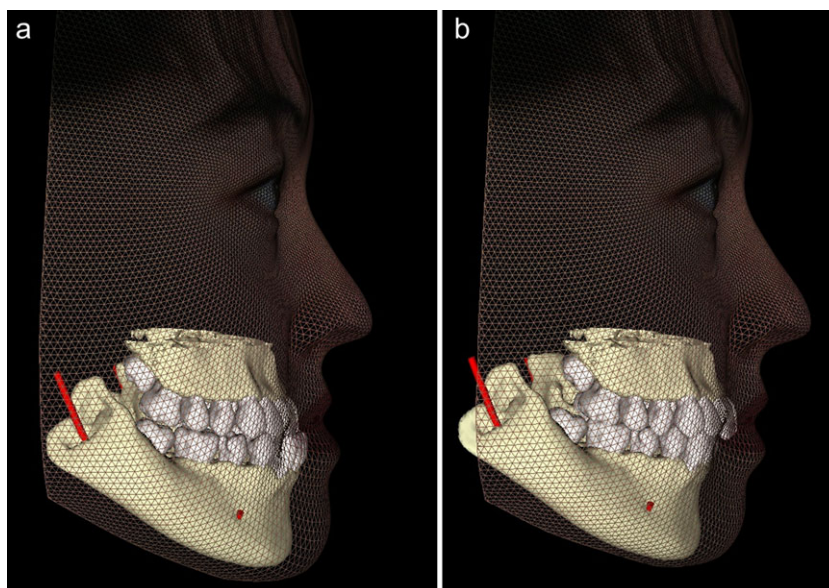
Pre-surgical facial surface image integrated with CBCT derived virtual models of the jaws with highlighted mandibular neurovascular contents (a) shows the effect of Class III skeletal relationship to the dental profile. Predictive orthognathic virtual surgery of the 3D models shows the predicted effect on the facial profile (b). (Images courtesy of Anatomage, San Jose, California, USA).
